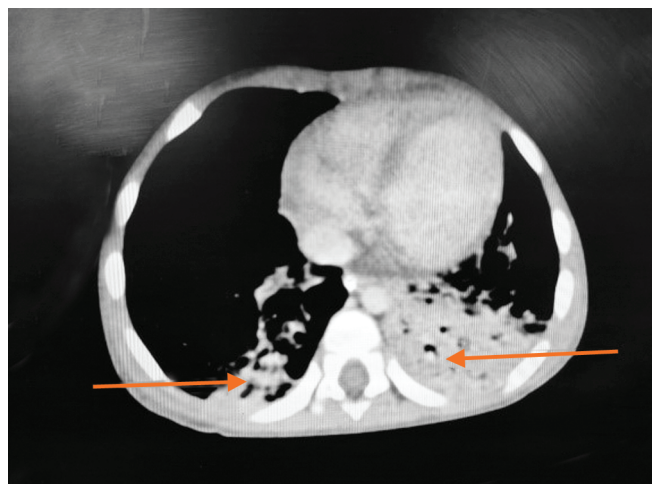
CT thorax (axial cut section) showing bilateral consolidation
